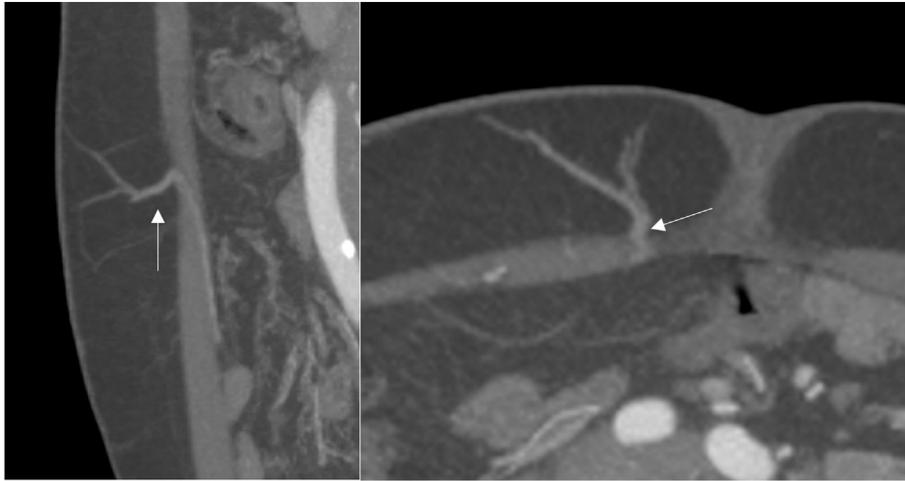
Sagittal and axial 5 mm MIP reconstructions from CTA of a 38-year-old woman demonstrating a good calibre right paramedian perforator (arising medial to the right rectus abdominus) measuring 2 mm in diameter (white arrows).
